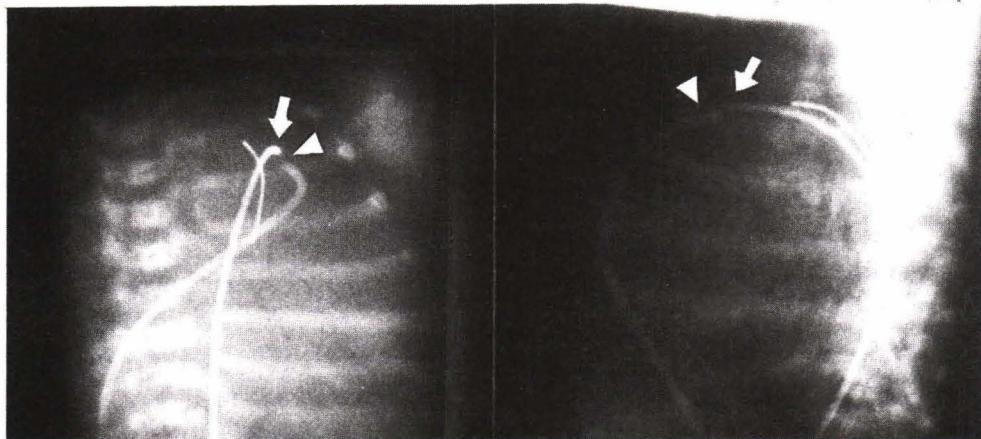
The plain films in A) anteroposterior and B) lateral views demonstrated the position of the catheter in blind infundibulum from venous route (arrow head) and in main pulmonary artery through patent ductus arteriosus from arterial route (arrow). The laser wire perforated the pulmonary valve and positioned in the proximal descending aorta through the patent ductus arteriosus.
